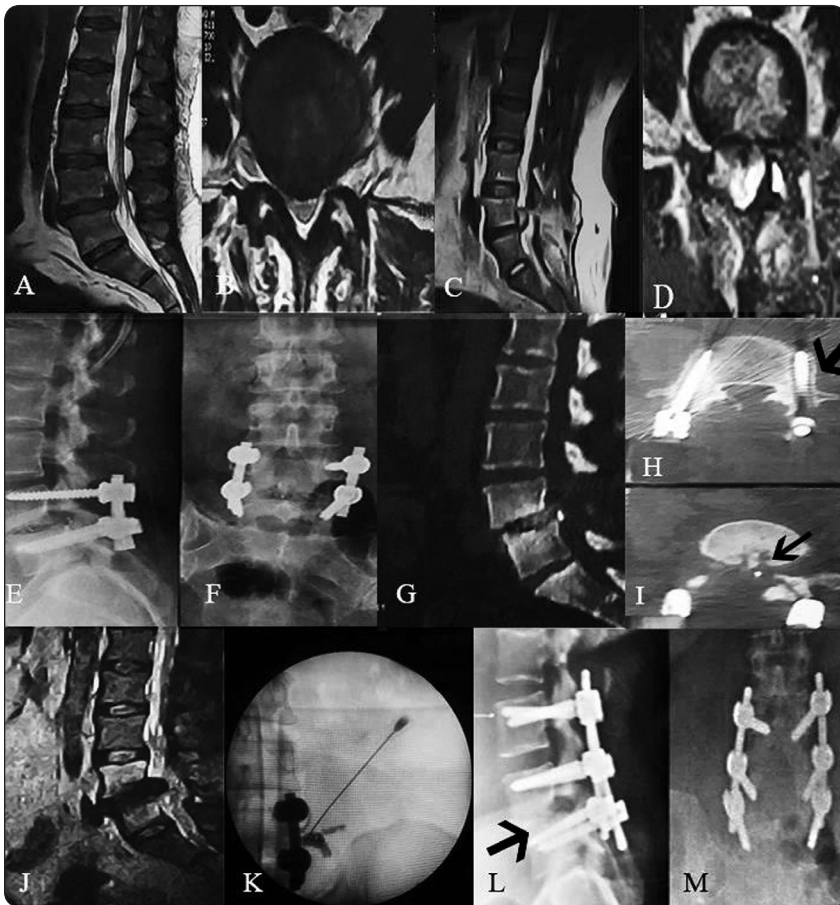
Cage retropulsion in 39 years old female. (A,B) Preoperative MRI T2 sagittal and axial radiographs revealed large disc and degenerative spondylolisthesis L4/L5. (C,D) Postoperative MRI T2 sagittal and axial radiographs revealed residual disc and fenestration laminotomy. (E,F) Lateral X-ray film revealed loosening of the L4 screws and retropulsion of the cage. (G,I) Lumbar CT sagittal cut and L4/L5 axial cuts showed cage retropulsion and loosening of L4 screw (black arrow) with the cage inside the canal (black arrow). (J) MRI T2 sagittal and axial radiographs revealed large cage shadow inside the canal. (K) Selective nerve root block. (L,M) Plain-X ray at six months later after construct augmentation by L3 screws and application of interbody bone graft only due to wide posterior disc space height (evident in CT sagittal cut), showed early bony fusion at L4/5 (black arrow).
